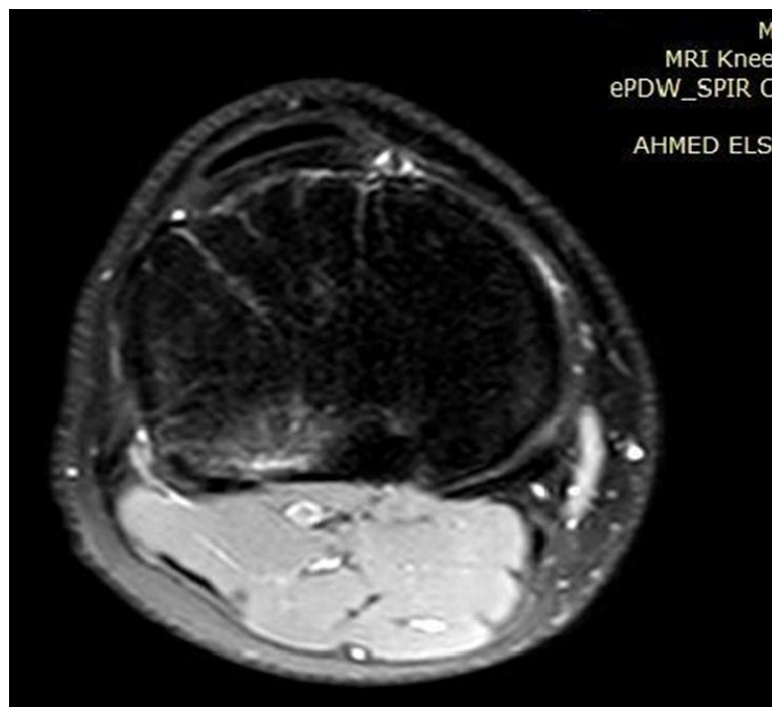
knee MRI image demonstrating high signal on fat suppression sequence diagnosed as marrow contusion in posterior tibial condyle.
